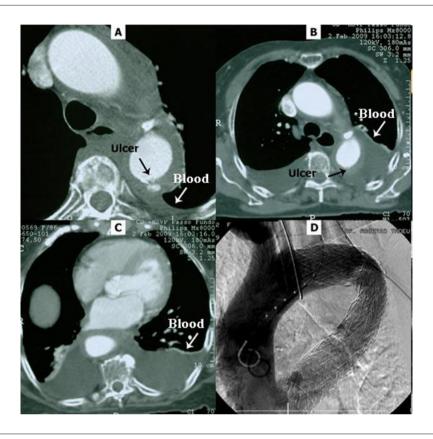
A - chest CT on admission revealing a penetrating ulcer and left pleural effusion; B and C - chest CT on the 10th day after admission demonstrating progression of the hematoma and extensive bilateral pleural effusion; and D - aortography after stent implantation.
